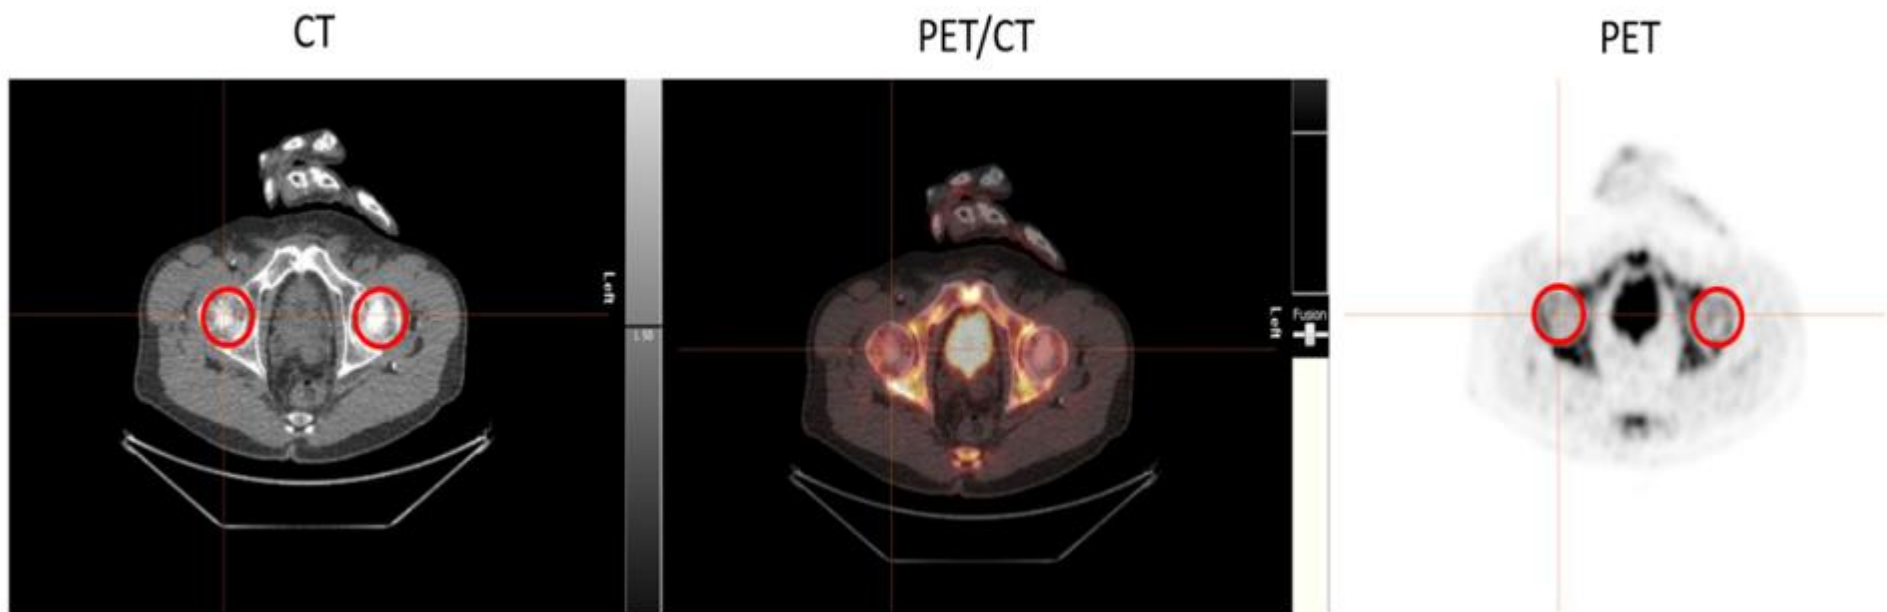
^{18}F -NaF PET/CT axial slice of the head of the femur.
